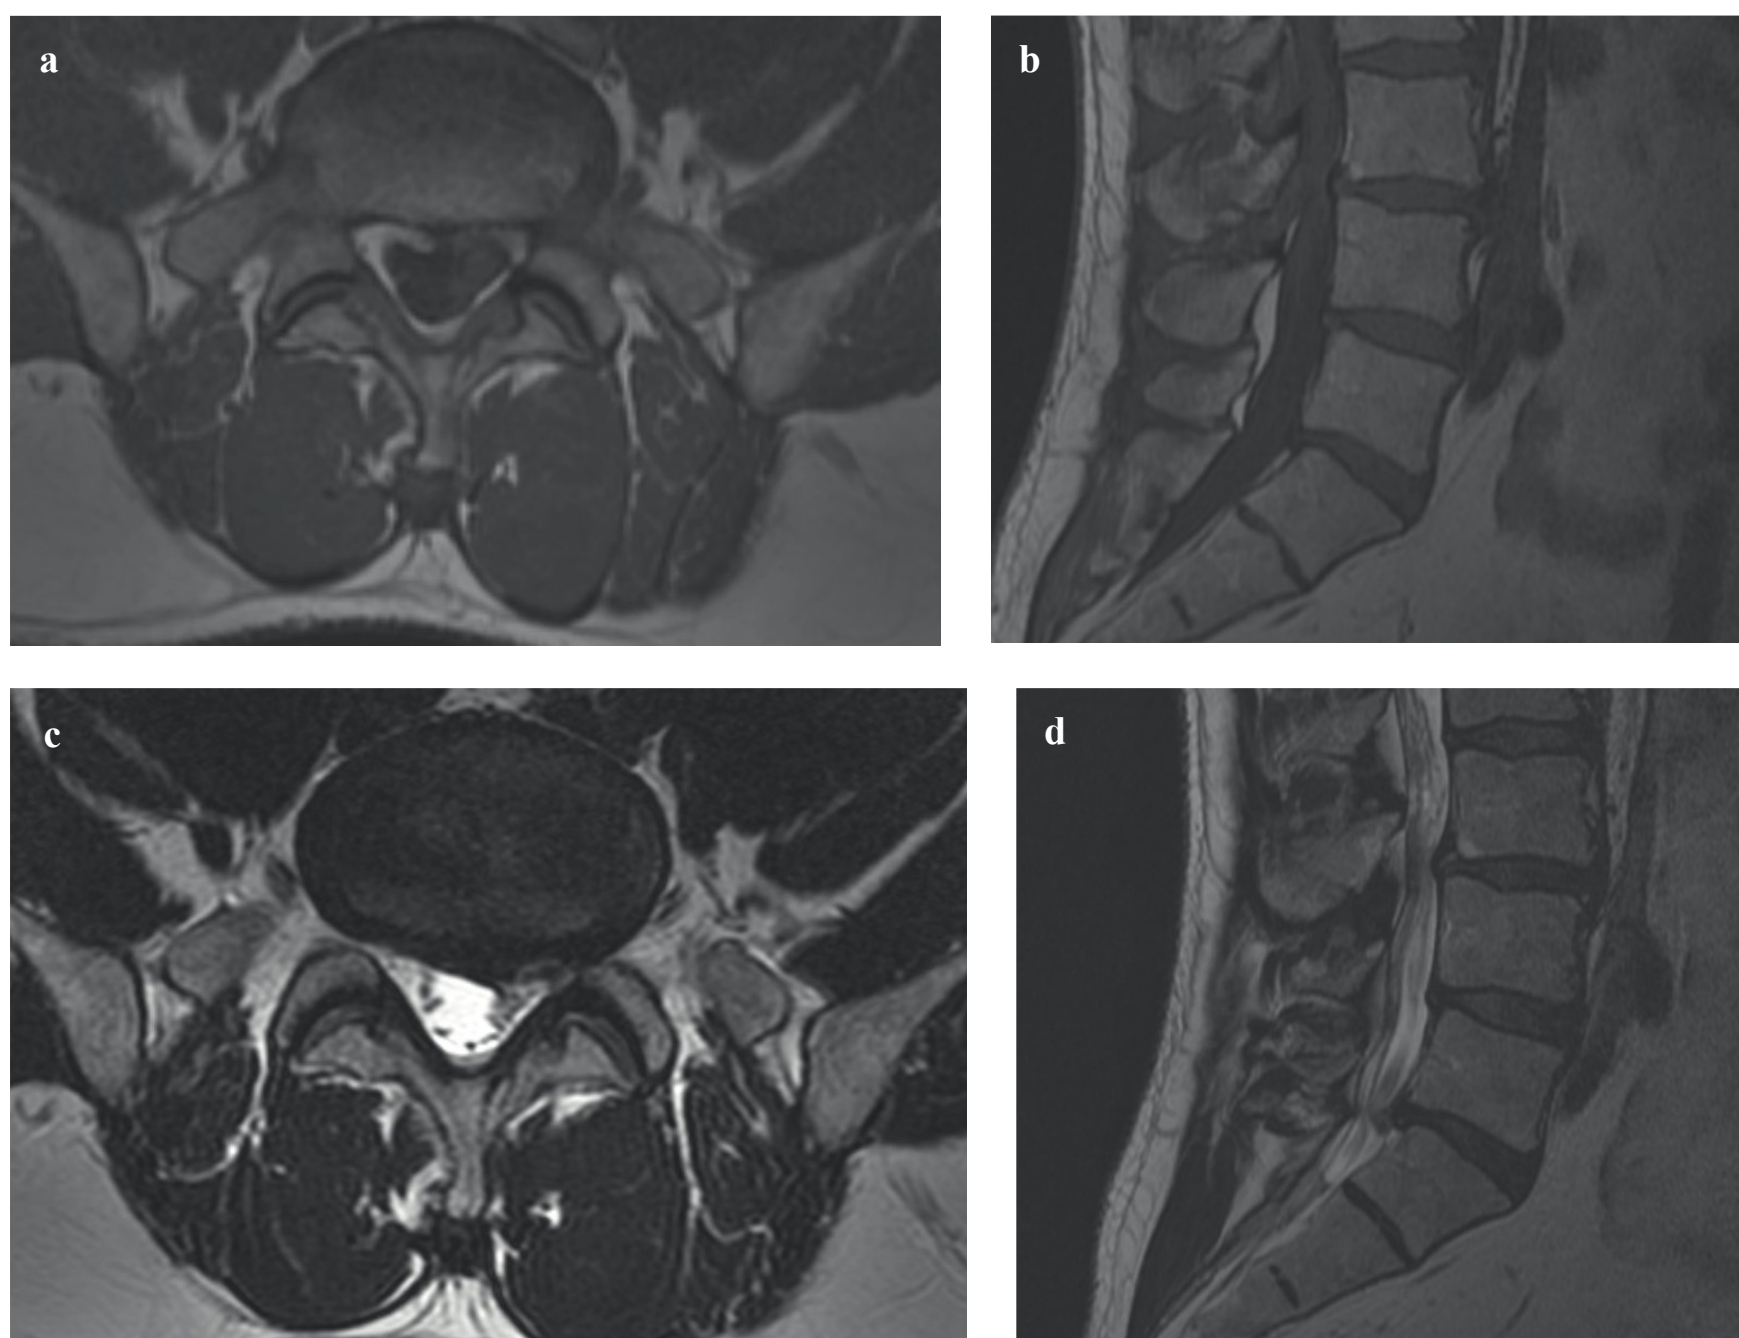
(a,b) T1-weighted magnetic resonance imaging (axial and sagittal) of the lumbar spine. (c,d) T2-weighted MRI imaging (axial and sagittal) of the lumbar spine.
